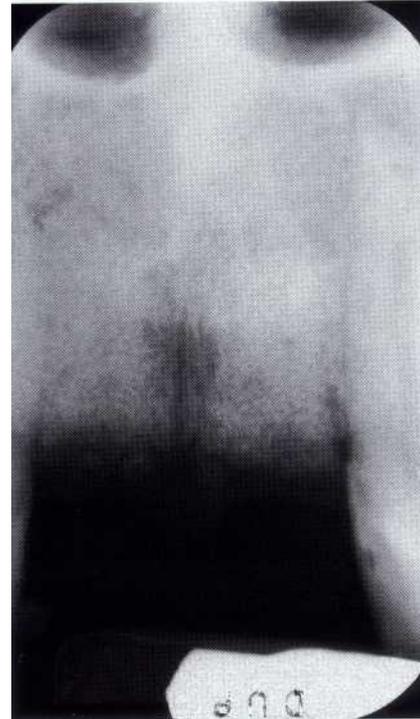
Postoperative radiograph taken 6 months later shows good bone consolidation. (Courtesy Jorge Barrios.)
